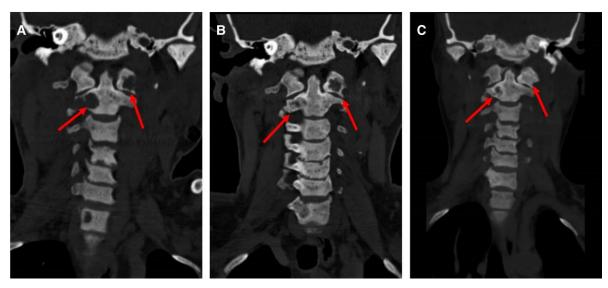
A cervical spine computed tomography scan showing multiple lytic lesions (arrows) before (A) subtotal parathyroidectomy and remarkable improvement (B) 7 and (C) 15 weeks after surgery.
